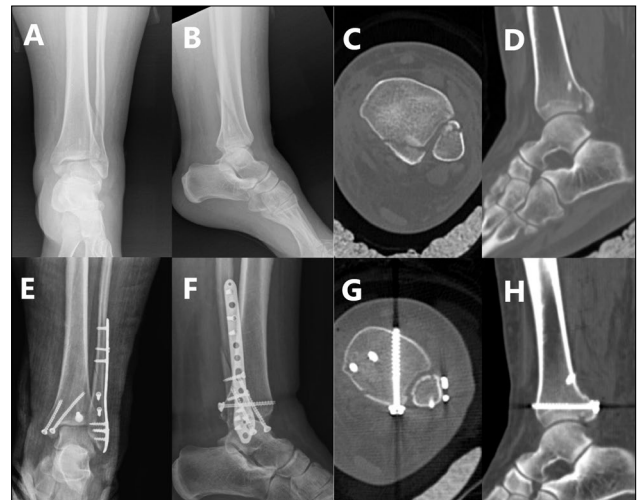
Pre-operative and post-operative anteroposterior radiograph (a,b,e, and f) and computed tomography (c,d,g, and h) images of the patient with posterior-anterior screw fixation.
